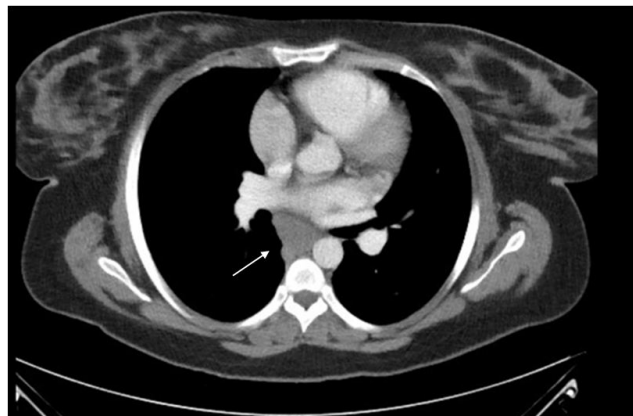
CT chest showing periesophageal mass.
